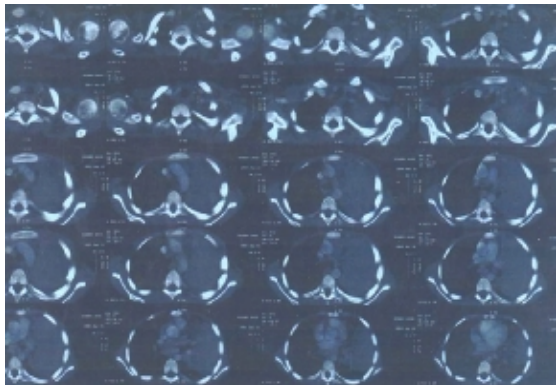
Computed tomography of the chest shows opacity in the left upper lobe suggestive for malignancy.
